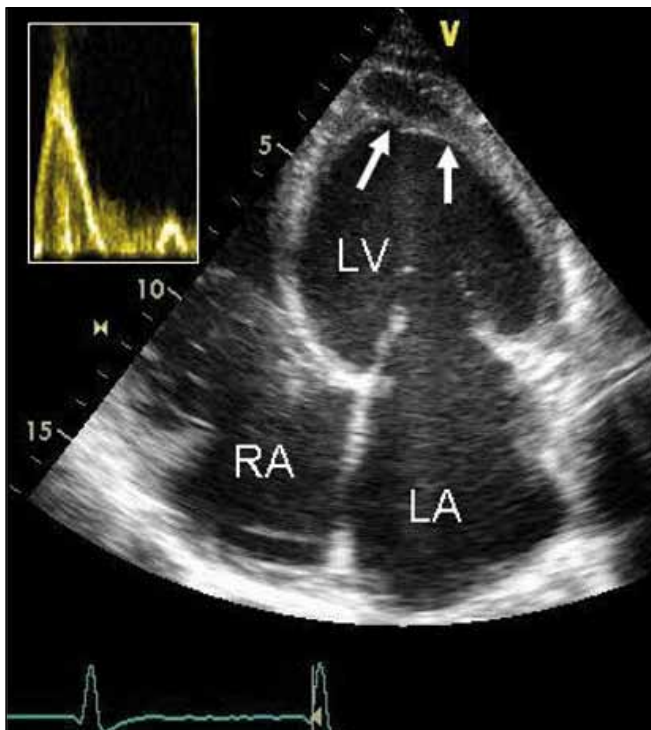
Transthoracic echocardiogram. Four chamber view showing a globular looking left ventricle (LV) with the suggestion of a rim of apical thrombus (white arrows). Doppler image shows a restrictive ventricular inflow pattern with an E:A ratio of 3.5. LA = left atrium; RA = right atrium.
